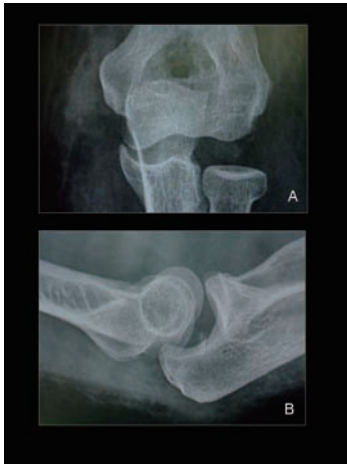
A 23 year old man (Case number 10) sustained left elbow dislocation after a fall during mountain hiking. After closed reduction, plain radiographs of the elbow anteroposterior (A) and lateral (B) view show wide gap in the radiocapitellar joint and persistent subluxation.
